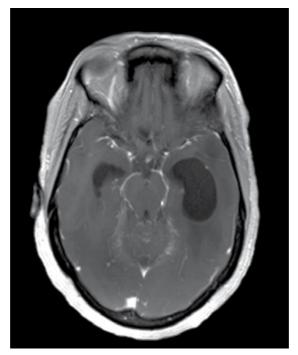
Gadolinium enhanced MRI of the brain demonstrating basilar leptomeningeal enhancement and hydrocephalus
